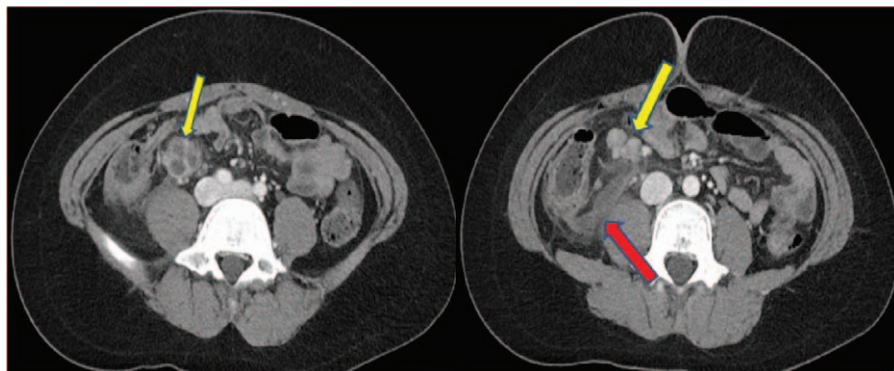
Computed tomography scan after 2 weeks later after laparoscopic appendectomy: (A) abscess pocket at ileocolic area, (B) enlarged lymph nodes (yellow arrow), fluid collection at ileocolic area (red arrow).
